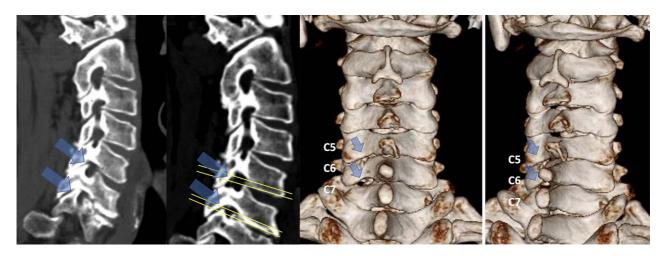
Postoperative CT revealed well-decompressed neuroforamen.
